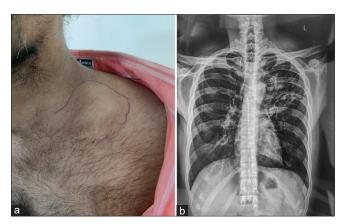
(a and b) Patient with left supraclavicular lymphadenopathy. Chest X-ray showing the hilar prominence
